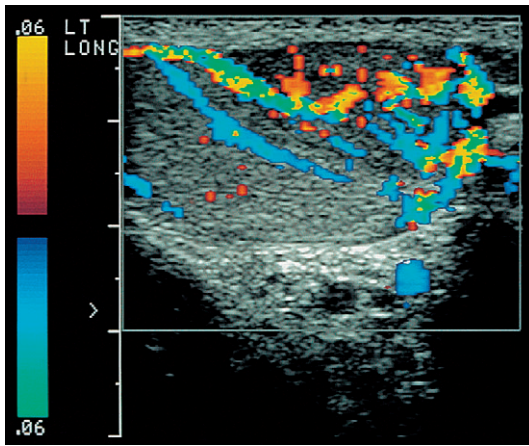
Longitudinal colour Doppler image of a testicle. This patient complained of severe scrotal tenderness. A focal hypoechoic of the lower pole shows marked hyperaemia in contrast to the upper pole. The diagnosis was focal orchitis.
